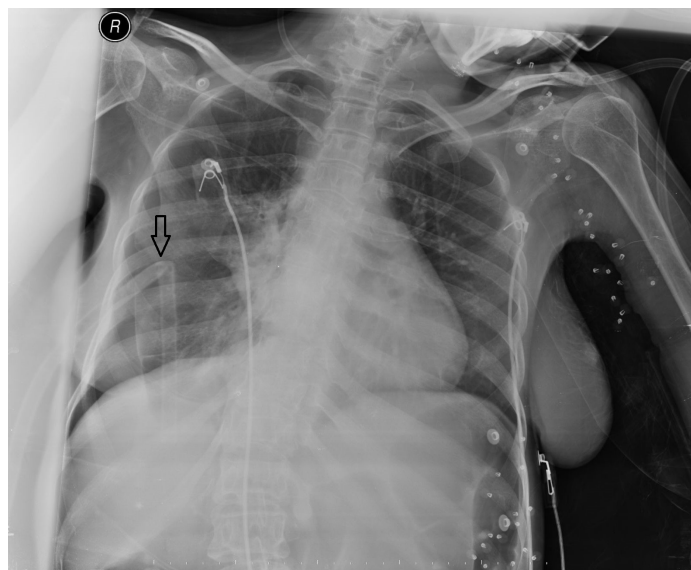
First chest X-ray after chest tube placement and malposition of the tube from king to basal
